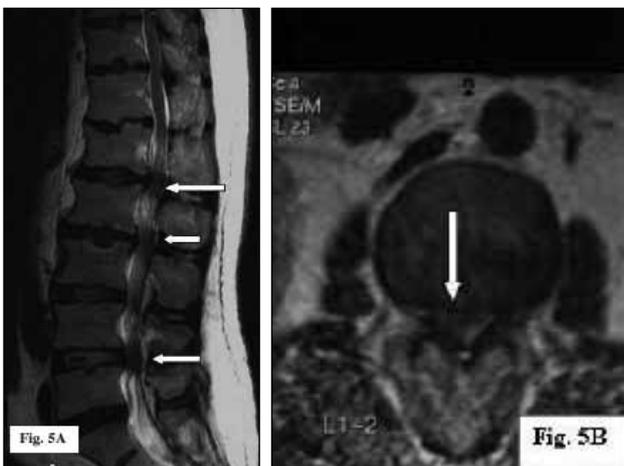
MRI of case 8: Sagittal (5a) and axial (5b) T2-weighted MRI demonstrated subtotal spinal canal obstruction due to migration posterolateral to the thecal sack at the L4-L5 level and associated multilevel disc herniation (arrow)
